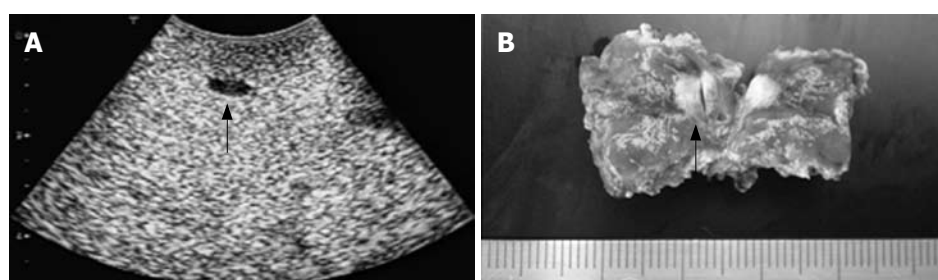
An occult metastasis. A: An occult metastasis at the segment 4 only detected by CE-IOUS. A clear hypoechoic mass (approximately 6 mm in diameter; black arrow) was newly detected at the delayed Kupfer phase. This metastatic lesion could not be found by CT, MRI, and IOUS. B: Macroscopic view of this metastasis (arrow).
